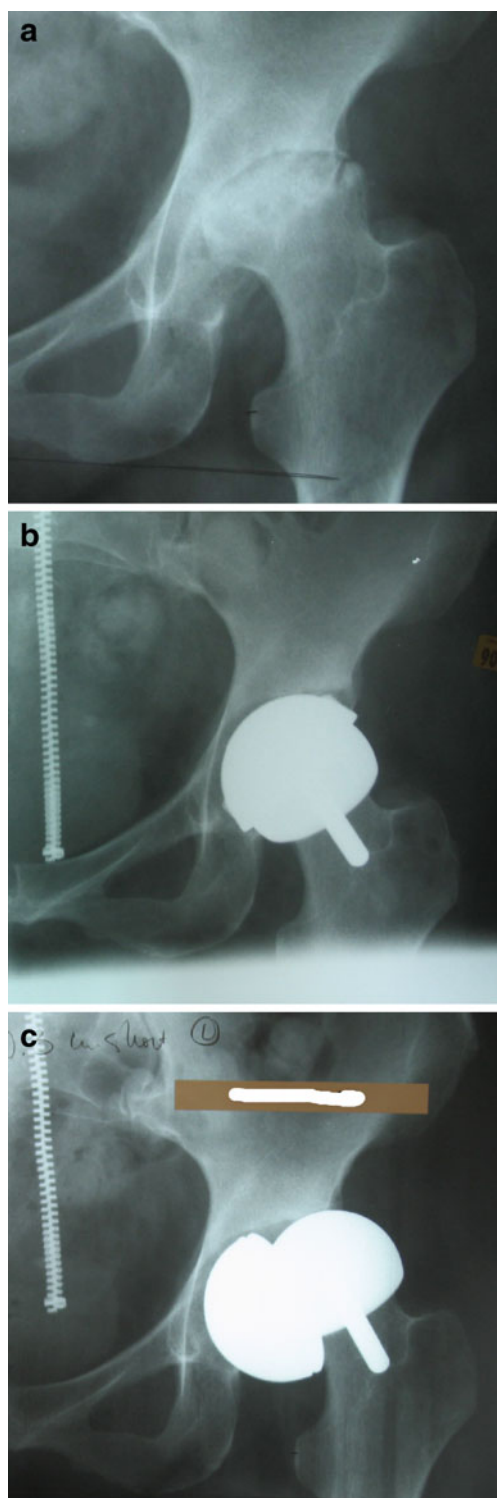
X-ray of female dysplasia patients before metal-on-metal hip resurfacing arthroplasty (a), after hip resurfacing arthroplasty (b), and failure of acetabular fixation (c)
